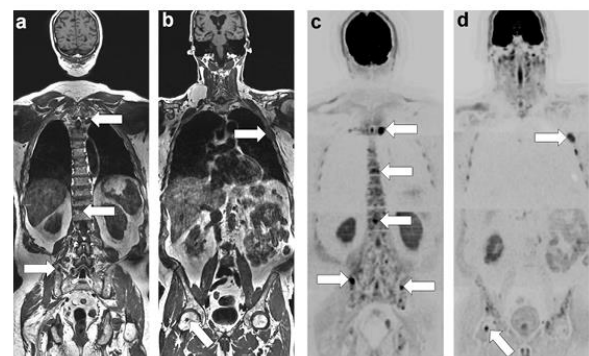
Newly diagnosed multiple myeloma in a 63-year-old patient: whole body MRI workup. Frontal T1 sections (a, b) and diffusion imaging (c, d): multiple foci of spinal cord replacement within the thoracolumbar spine and pelvis (arrows in a and c), costal gril, and right femoral head (arrows in b and d) signaling advanced disease requiring therapeutic management.
